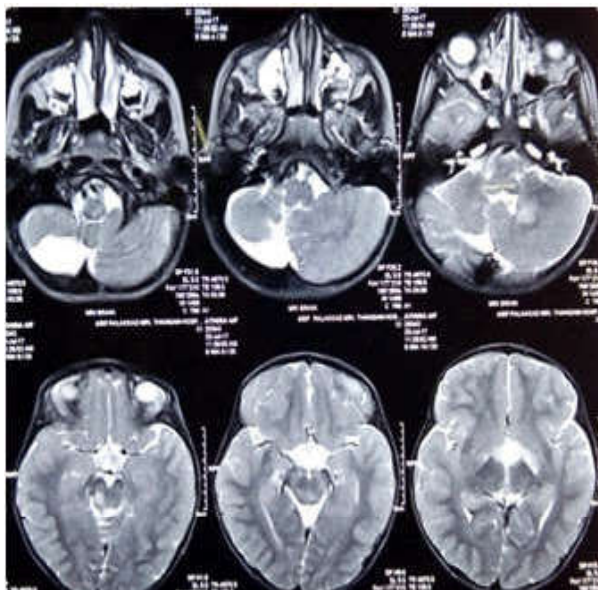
Hyperintensity of midbrain on T2 and FLAIR with no contrast enhancement in T1 weighted image(UBO) and in left cerebellum. In addition there is right cerebellar hypoplasia
